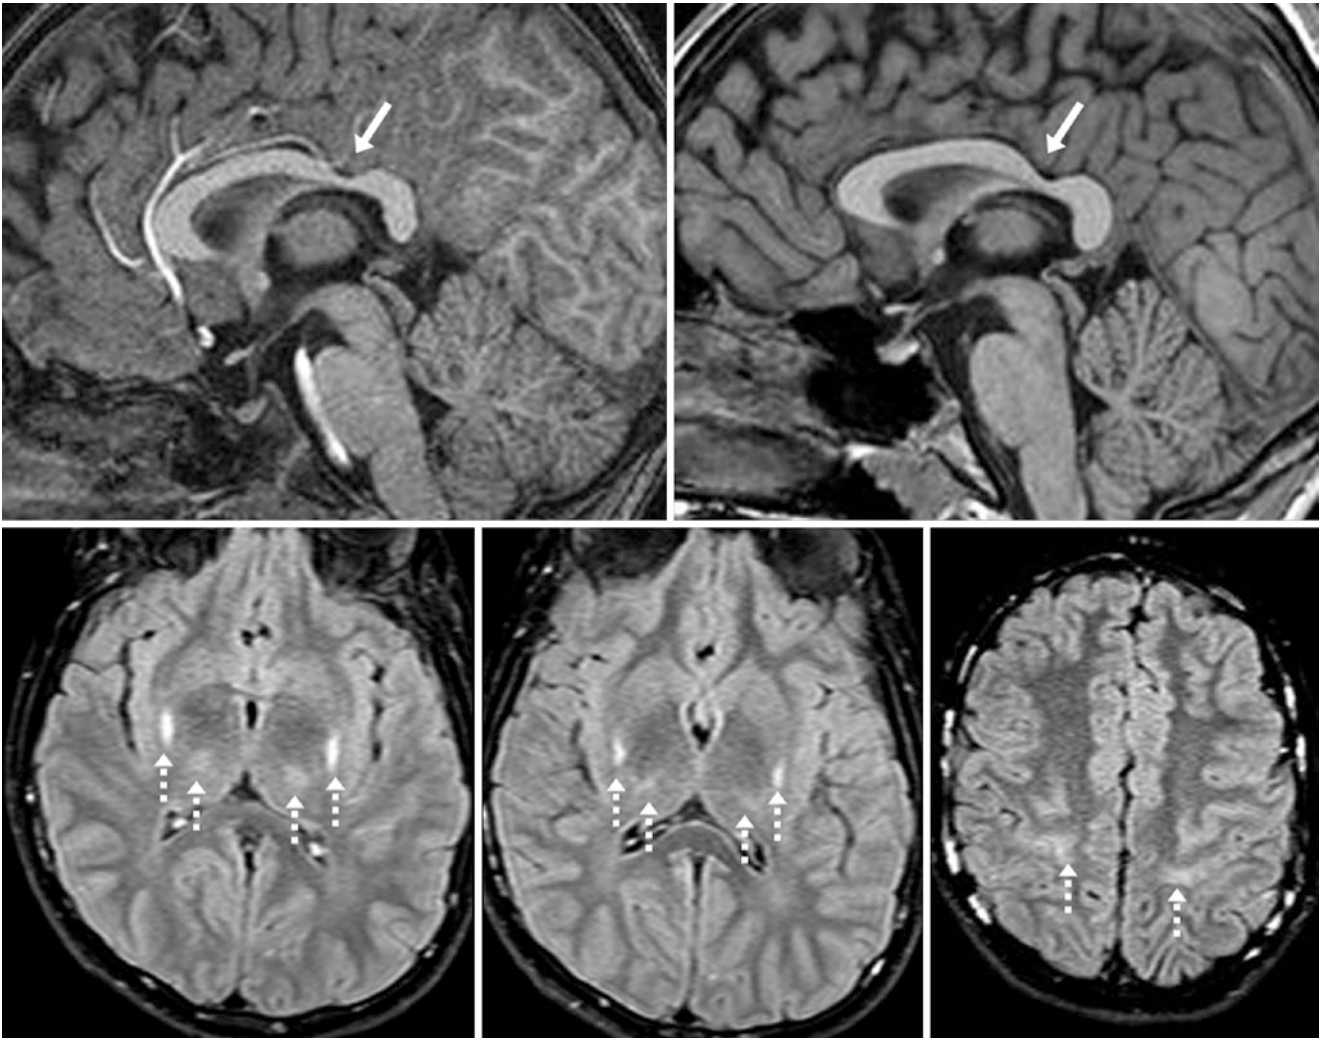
Comparison case of atrophy from remote perinatal ischemia. In a 6 year old born with a history of a perinatal insult, a 1.5T MRI depicted severe atrophy of the posterior callosal body and isthmus (arrows) on a sagittal T1WI (top left), unchanged 10 years later on a
